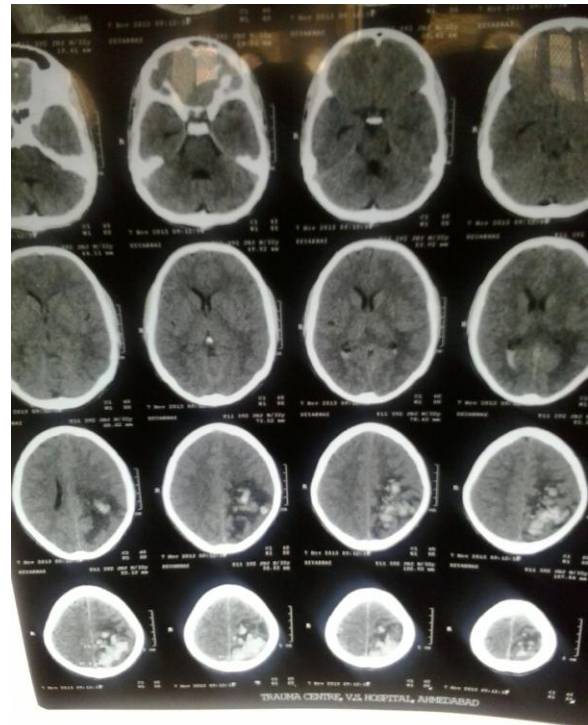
(CT scan brain showing a moderate (58x35 mm) intraparenchymal hemorrhage in left high parietal region with perilesional edema and seepage of blood in occipital horn of both lateral ventricles)
